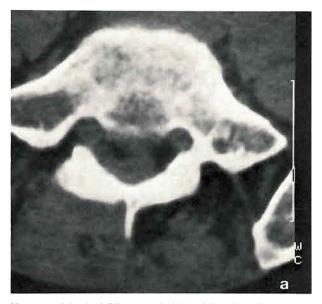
a. Axial spinal CT scan at the level of the 4th lumbar vertebra; within the spinal canal the epidural fat is absent suggesting spread of the abscess into the epidural space
